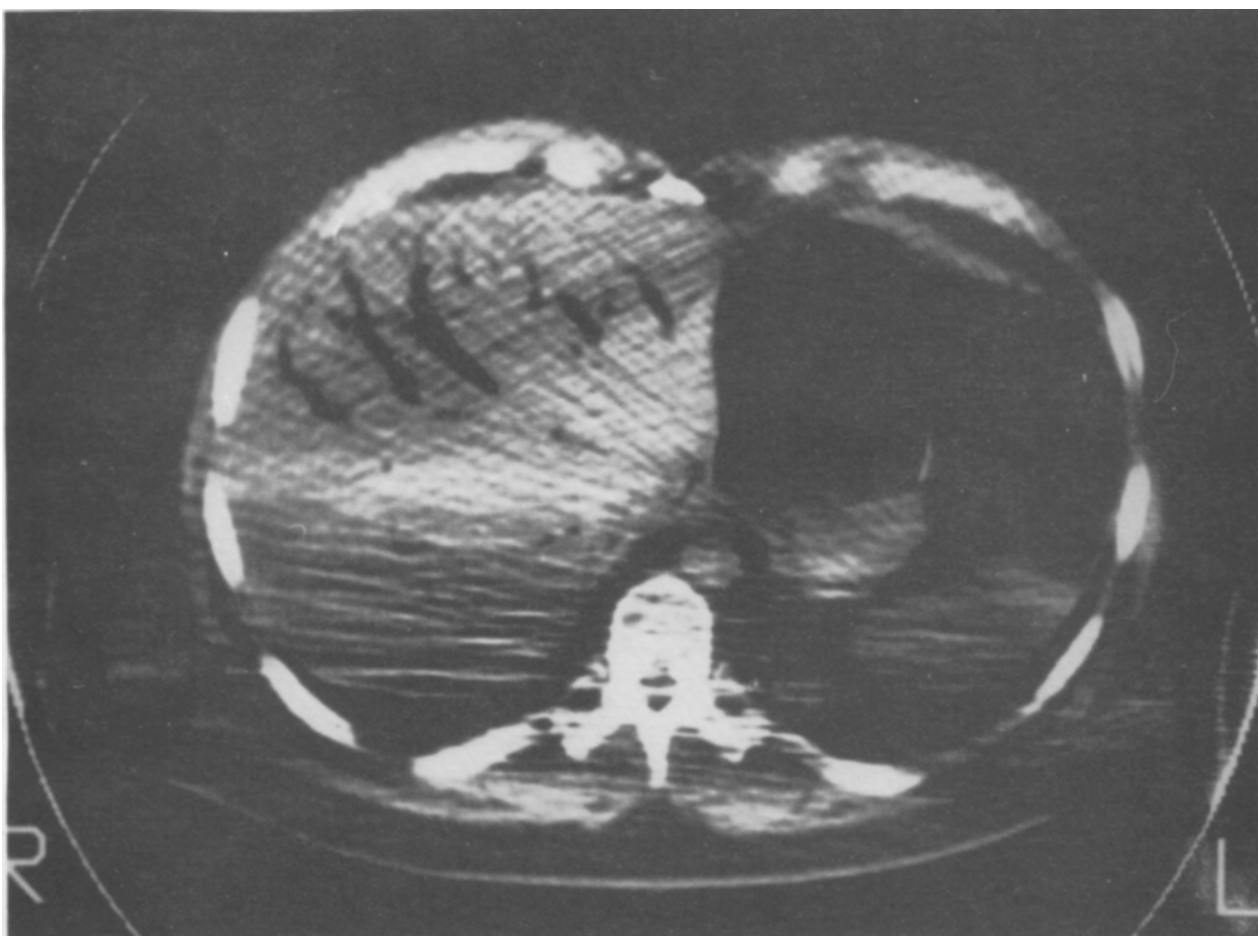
Postmortem CT of Case 2. Air (black lines) is shown in the blood vessels of the liver.
